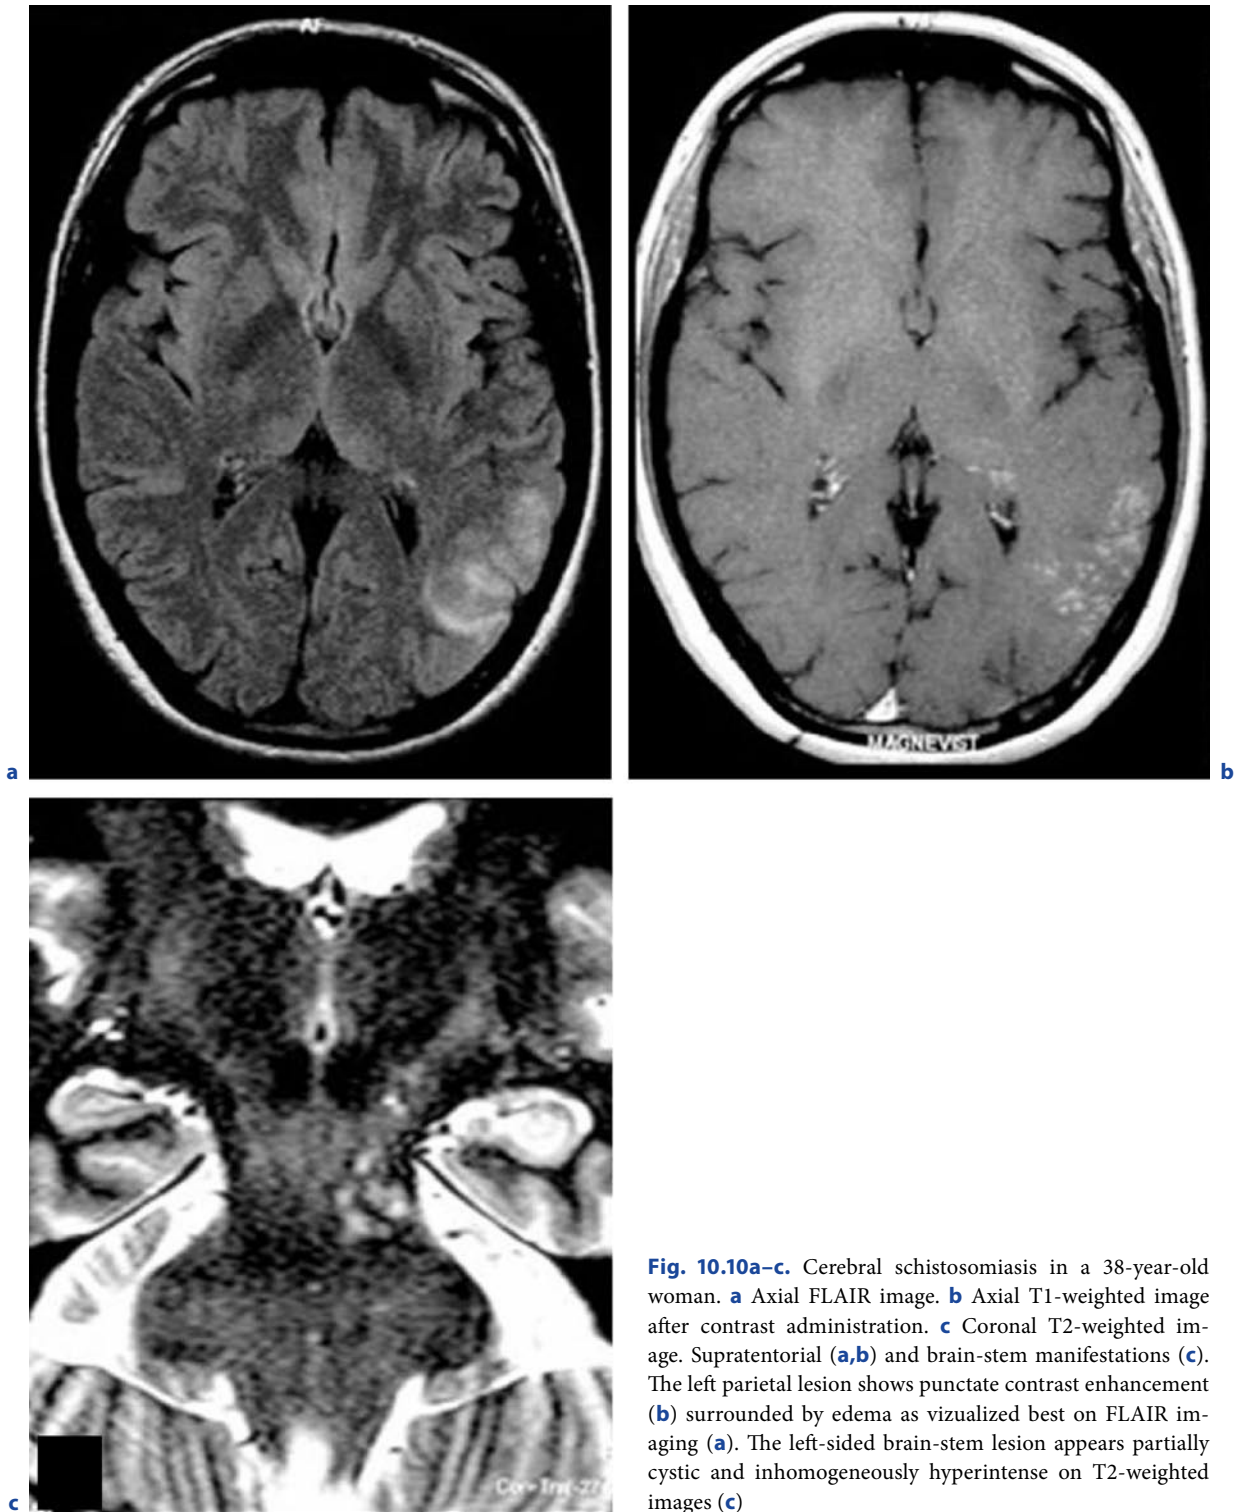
Cerebral schistosomiasis in a 38-year-old woman. a Axial FLAIR image. b Axial T1-weighted image after contrast administration. c Coronal T2-weighted image. Supratentorial (a,b) and brain-stem manifestations (c). The left parietal lesion shows punctate contrast enhancement (b) surrounded by edema as visualized best on FLAIR imaging (a). The left-sided brain-stem lesion appears partially cystic and inhomogeneously hyperintense on T2-weighted images (c)
